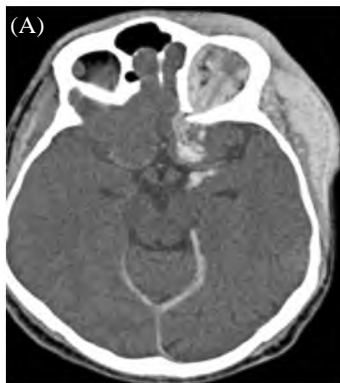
Post contrast axial CT brain A-C, and MRI (T1 (D) & T2 (E)) and post contrast T1 (F) for the 21-year old male with left proptosis, dark bluish swelling of the upper third of the left hemi-face, images show Diffuse mass lesion involving the left upper face with low T2 signal extending along V1,V2 nerve tract associated with meningeal lesions pathology revealed neurocutaneous melanosis.
